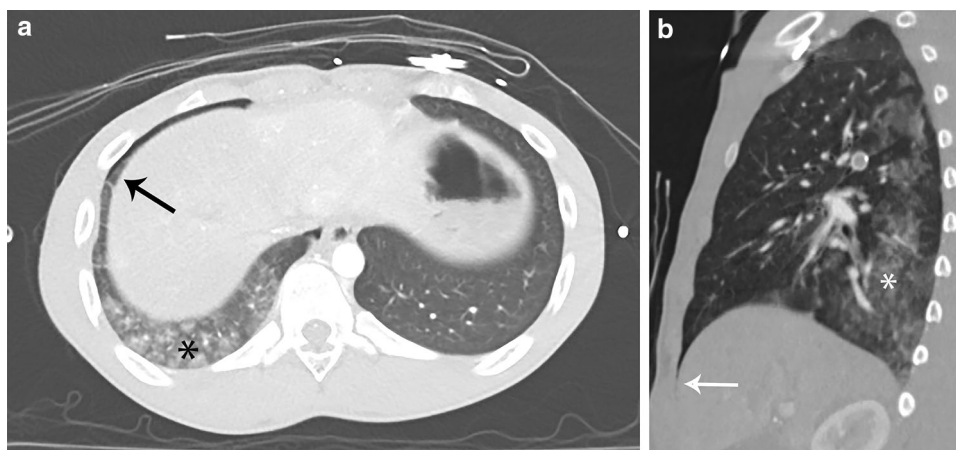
a Axial CTA image of the chest shows a lucency just anterior to the liver. A visceral pleural line is seen at the junction of the lucency and the adjacent lung confirming this as a pneumothorax. The edge of the lung can sometimes appear lucent in this region and may be a reason for a false positive identification of pneumothorax. Careful scrutiny of sagittal views (b) are very helpful to look for
